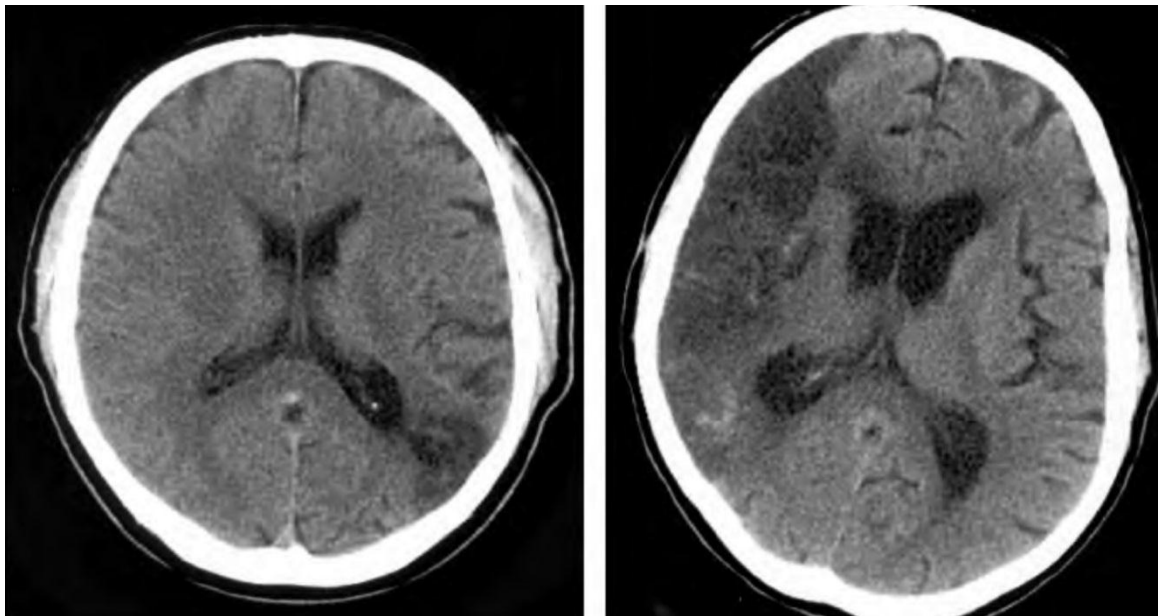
CT brain hypodense area in right fronto parietal area
